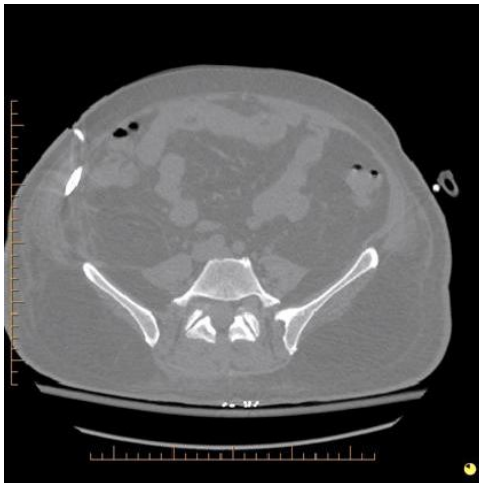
Axial CT at L2 level showing decompression
